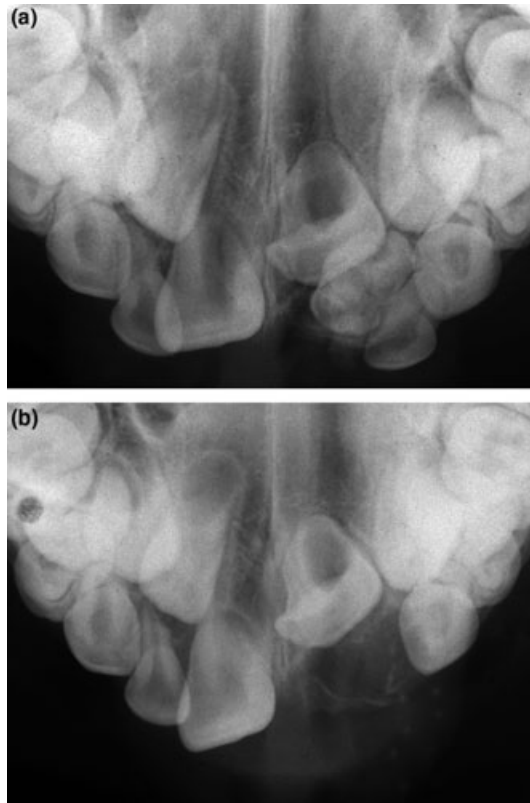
Radiographic image of the traumatized area before (a) and after surgical removal of the permanent lateral incisor (b).
